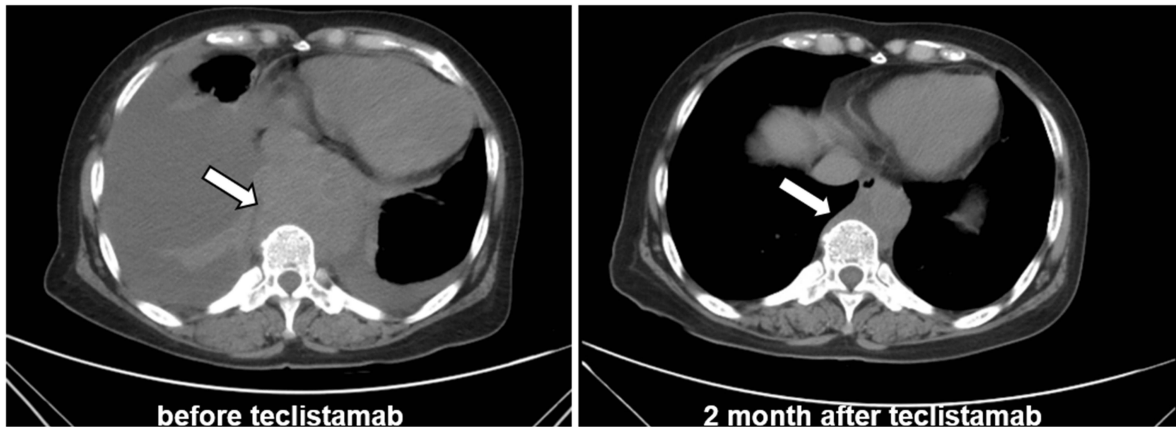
(A) Timeline of patient's diagnosis and treatment. (B) CT scan of plasmacytoma changes 2 months post teclistamab therapy, the white arrow indicates the extramedullary plasmacytoma.
